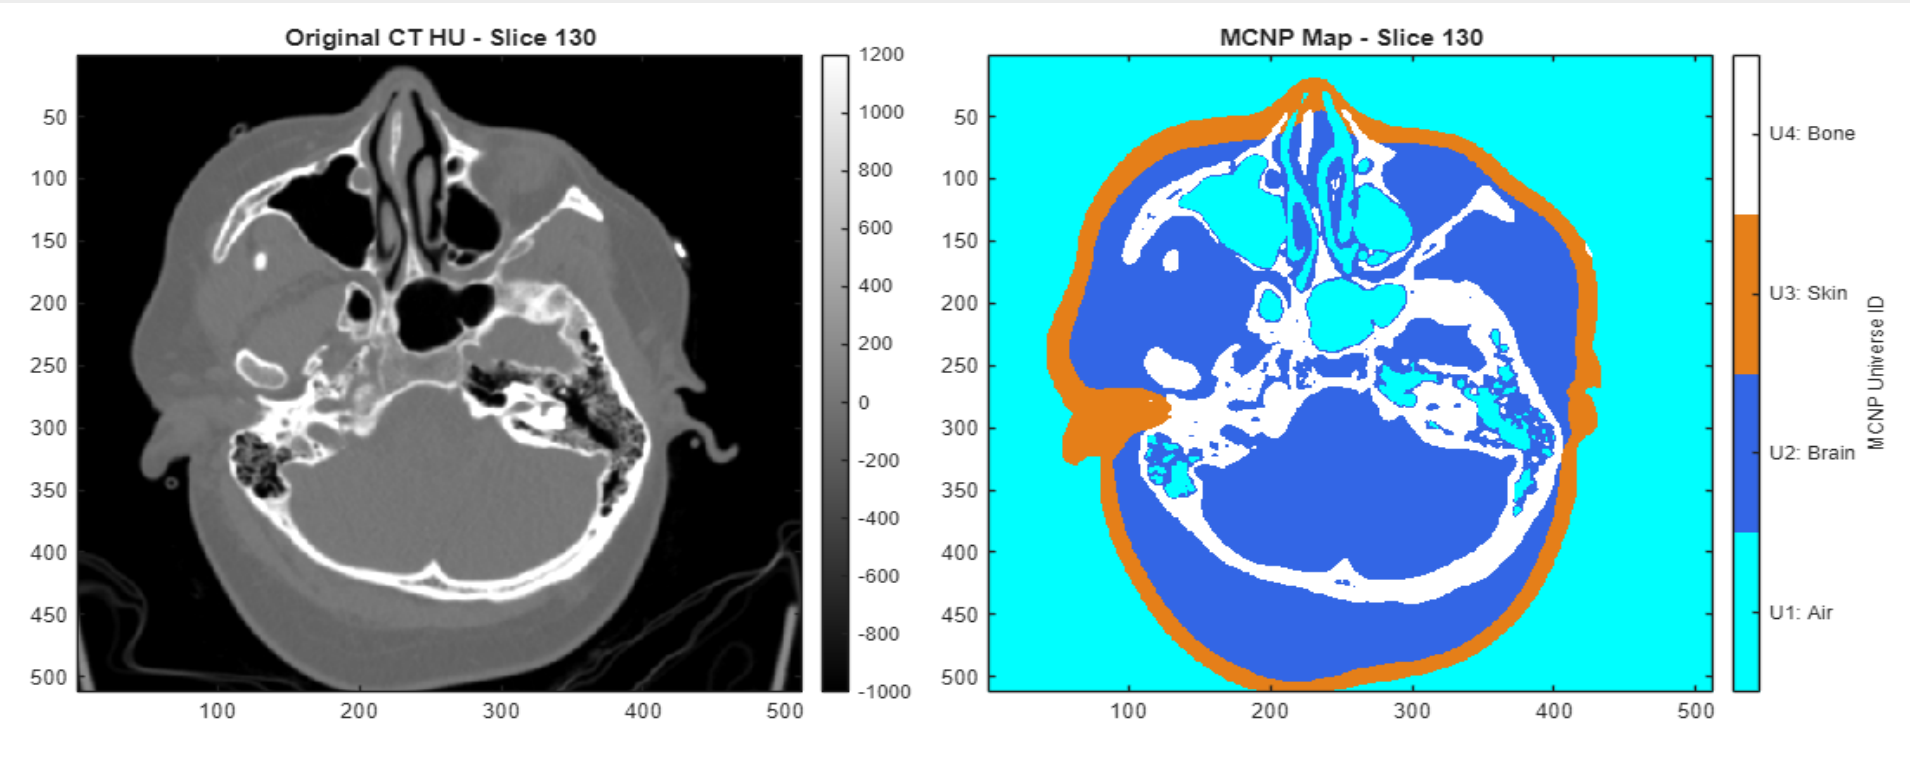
Verification of material map with original CT image. Left: original CT image, Right: material mapped image.
